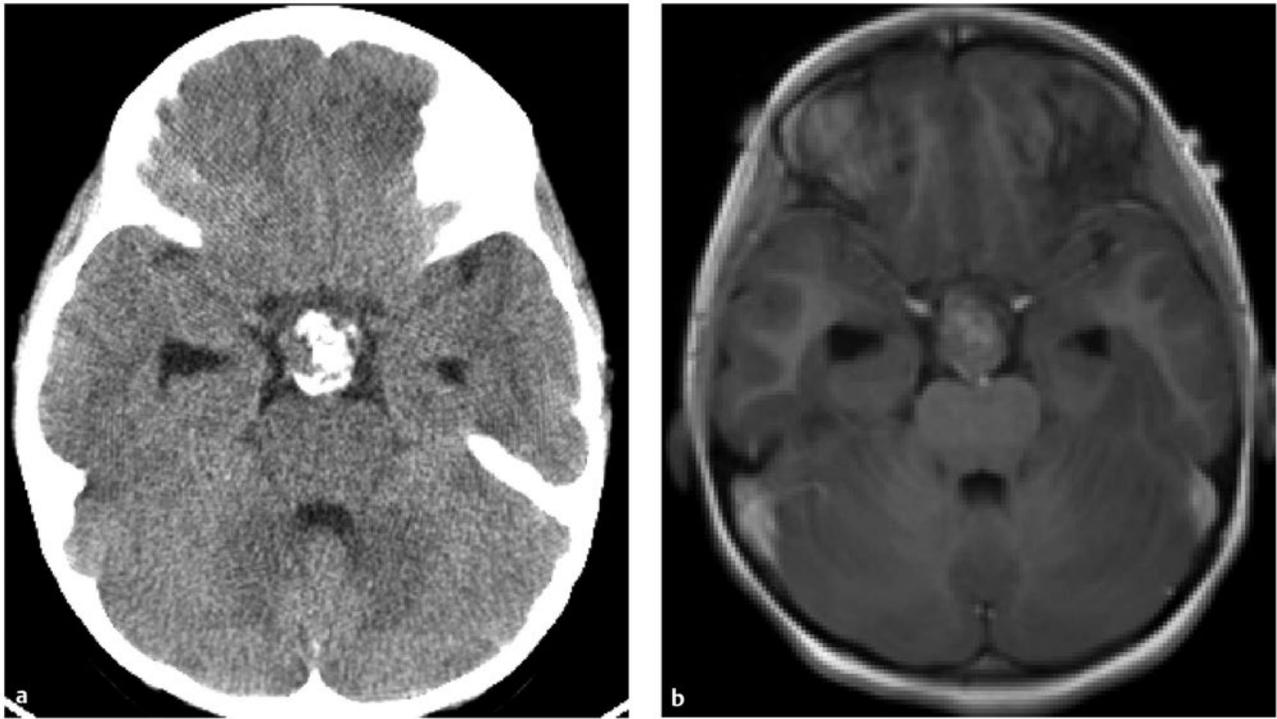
(a) Noncontrast computed tomographic (CT) scan demonstrating calcified portion of tumor. (b) Corresponding contrast-enhanced T1 axial magnetic resonance image. Note the nonenhancing portion, representing the calcification seen on CT.
